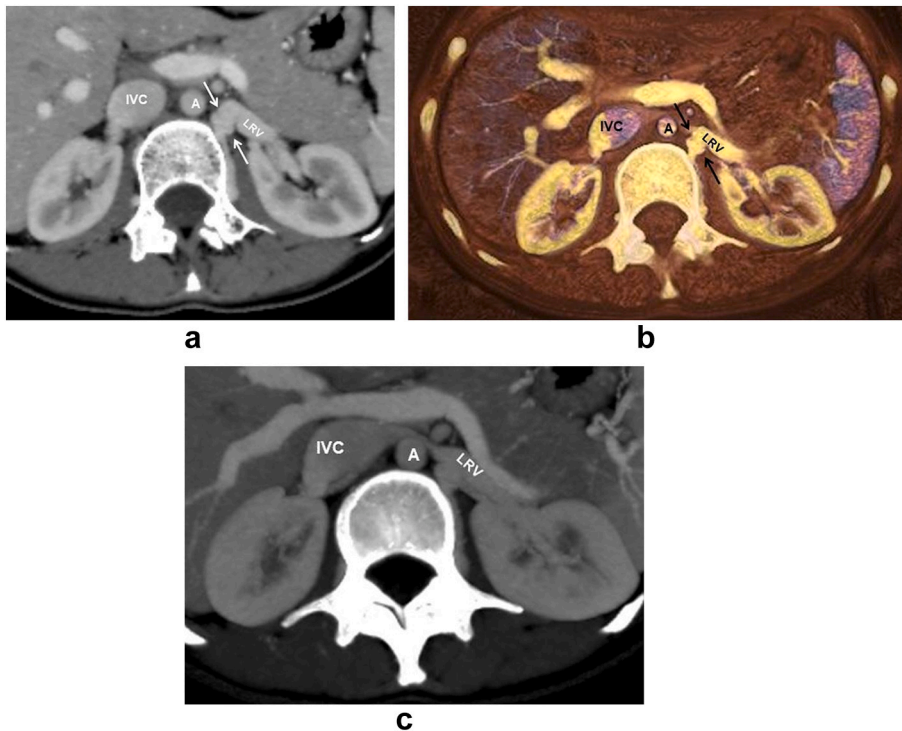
ALCV aneurysm in nutcracker phenomenon. A 27-year-old female patient presenting at the Emergency Department with right lower quadrant pain underwent a contrast-enhanced abdominal CT scan. (a) Axial plane CT and (b) VRT images show ALCV aneurysm (arrows). (c) Axial plane MIP CT image demonstrates compression of the LRV between the abdominal aorta and superior mesenteric artery compatible with nutcracker phenomenon (aortomesenteric angle = 13° , CR = 4). A: Abdominal aorta IVC: Inferior vena cava LRV: Left renal vein.
